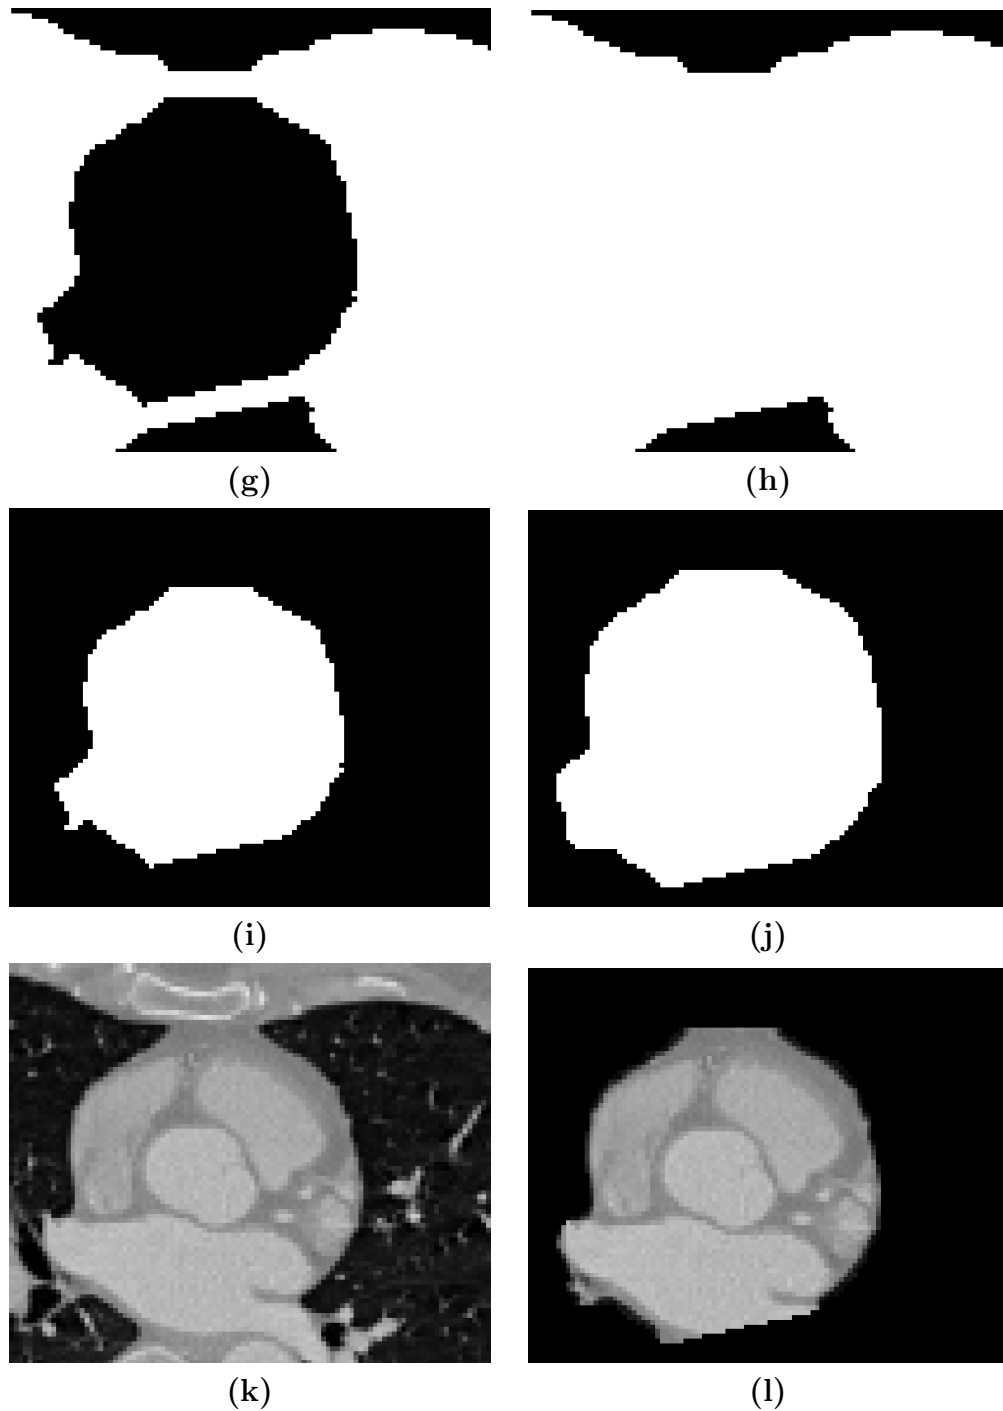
Original coronary artery CTA images, Dataset #1, Part II.
